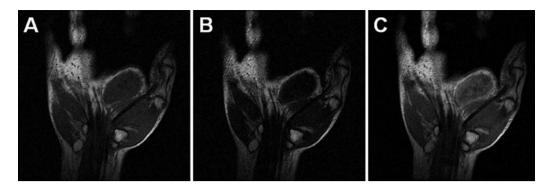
Coronal magnetic resonance images of fibroma of tendon sheath involving the first web space of the right hand. T1- (A) and T2- (B) weighted images exhibit a well-defined soft tissue mass with iso- to slightly-low signal intensity relative to skeletal muscle. Contrast-enhanced T1-weighted image (C) reveals moderate patchy enhancement of the mass.
